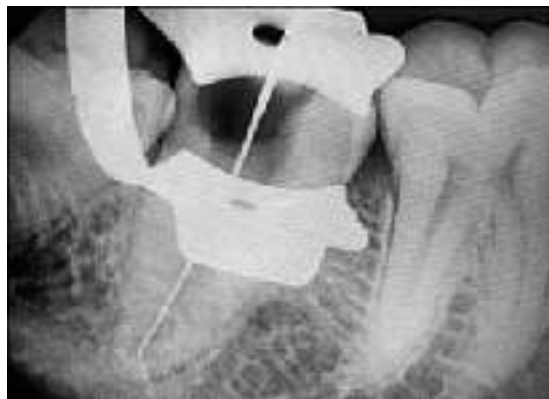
Radiograph of working length #47.
